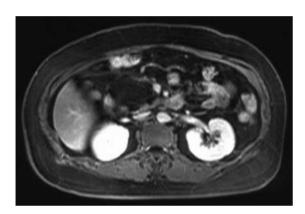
T1 weighted magnetic resonance imaging phase. This cross sectional image reveals a homogenous fatty containing lesion in the head of pancreas.
